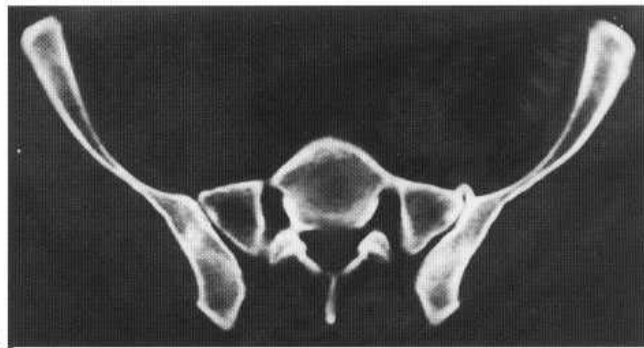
Sarcoid. (A) Multiple foci of sclerosis are a recognised, if uncommon, feature of sarcoid. (B) Sclerotic change in sarcoidosis demonstrated at CT scanning.
